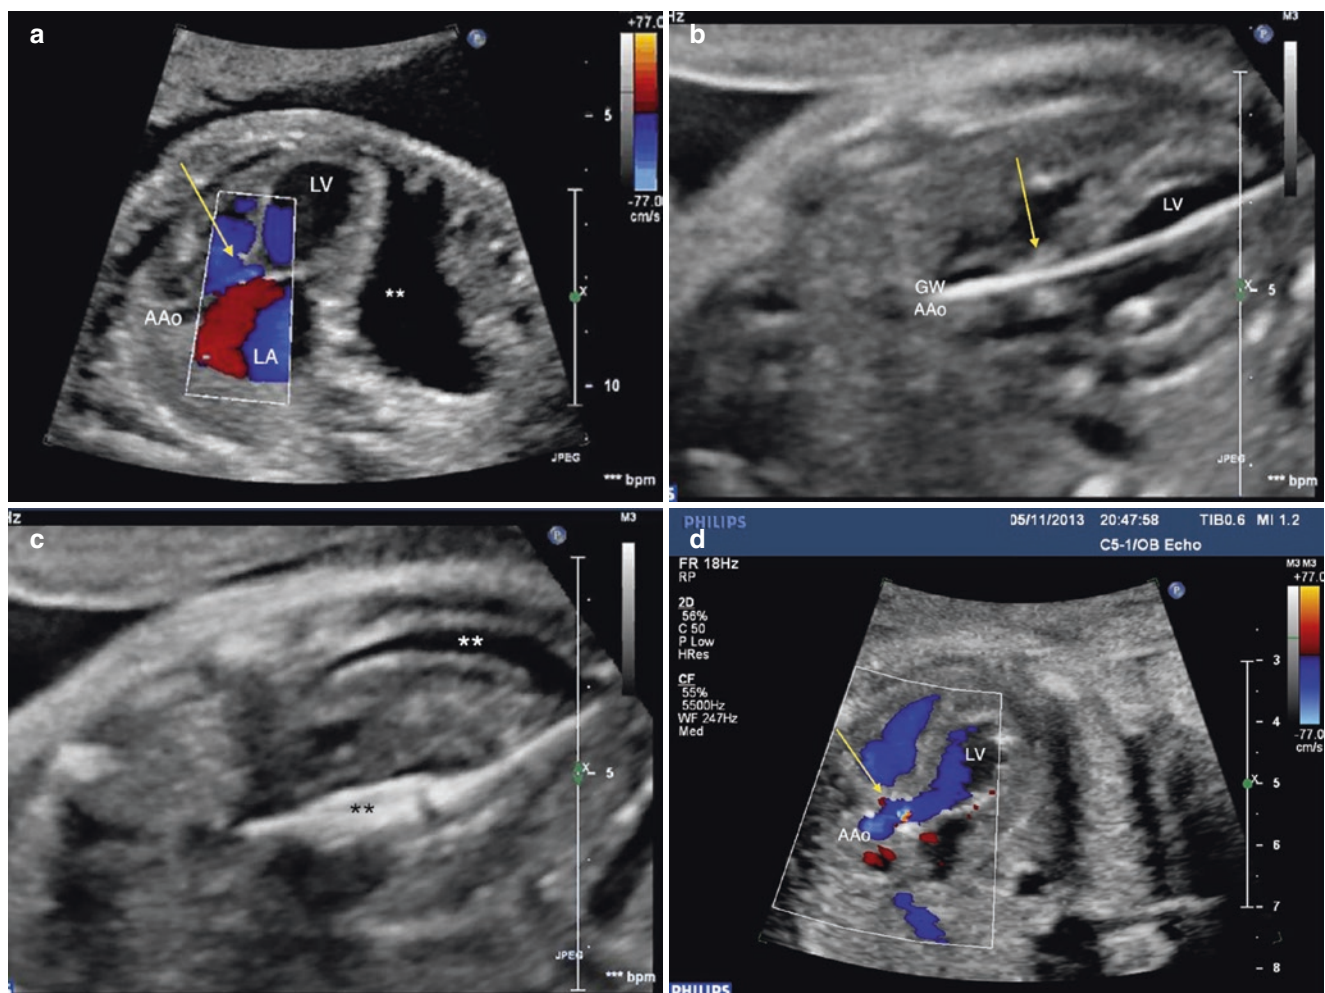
Critical aortic stenosis in a 26 weeks gestational age hydropic fetus. (a) Echocardiographic evaluation pre-intervention. There is a tiny forward flow (blue color) across the aortic valve (indicated by an arrow) as shown by color flow mapping. The LV is conspicuously dilated and dysfunctional. Hydrops results from severe in utero heart failure. Asterisks show ascites. (b) After crossing the aortic valve (indicated by an arrow), the guidewire is readily seen in the ascending aorta. (c) The
